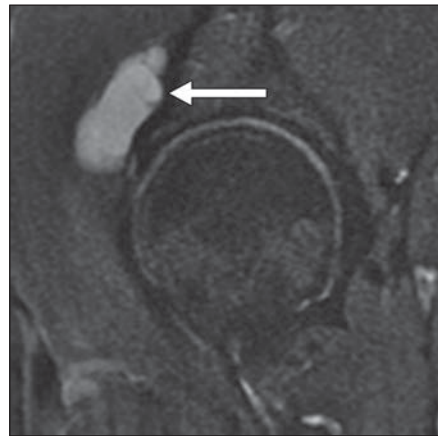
26-year-old man with iliopsoas bursa. Sagittal fat-saturated intermediate-weighted image shows iliopsoas bursa (*arrow*). Iliopsoas bursa is normally collapsed and not seen on MRI. In 15% of asymptomatic patients, there is direct congenital communication between hip joint and iliopsoas bursa. Direct communication can also be acquired from various inflammatory or mechanical conditions.
